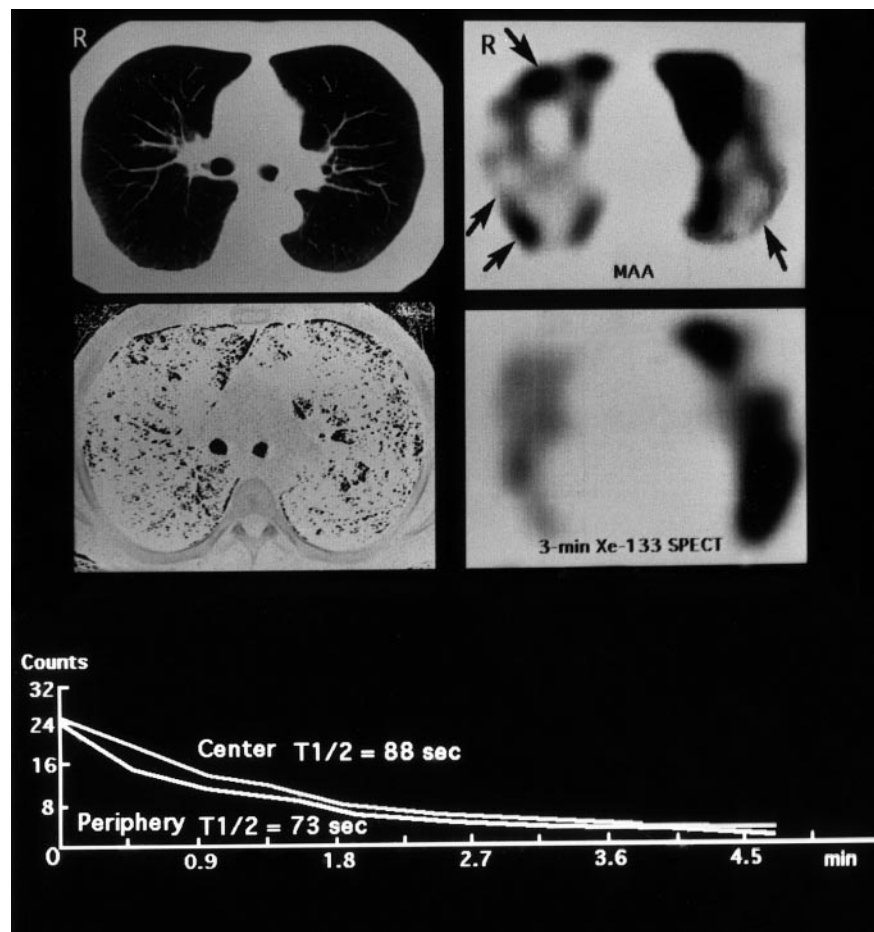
A 56-year-old man with a smoking index of 580. Chest CT scan (*top left*) does not show noticeable abnormalities in the lungs. The density mask CT image (*middle left*) shows only focal LAA, which is nearly even between peripheral and central lung. ^{99m}Tc -MAA SPET (*top right*) shows periphery-dominant perfusion with a stripe sign (*arrows*). ^{133}Xe SPET image 3 min after initiation of washout (*middle right*) shows heterogeneous ^{133}Xe retention throughout the lung. The time-activity curves in the right lung (*bottom*) show faster $T_{1/2}$ in the peripheral lung area than in the central lung area
